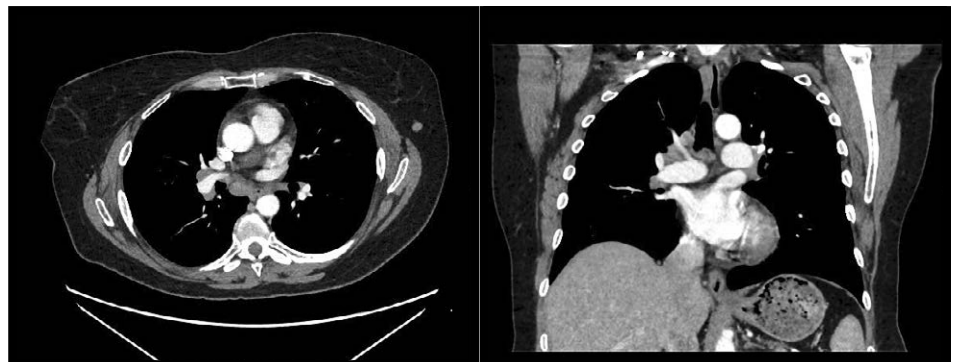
Axial and coronal contrast enhanced CT images of the chest show enlarged mediastinal and bilateral hilar lymph nodes. These are the most common radiographic findings of sarcoidosis.
